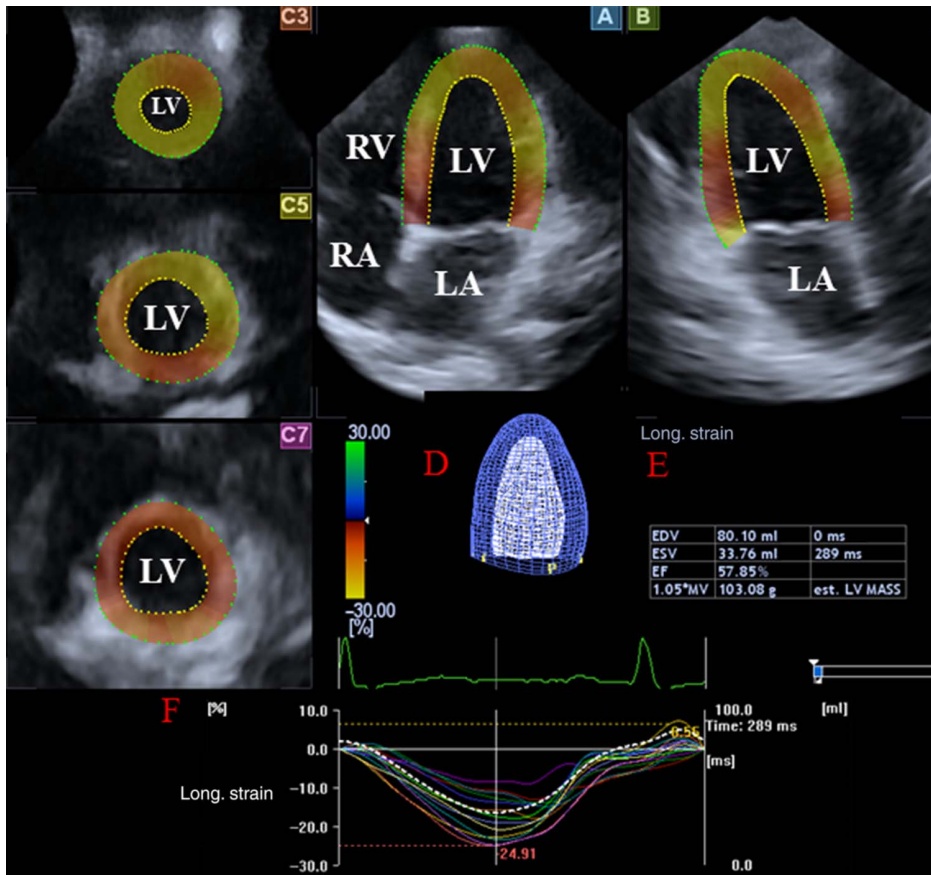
Different views of the LV extracted from the 3D echocardiographic data set are presented including apical four-chamber (A) and two-chamber views (B) and basal (C3), midventricular (C5), and apical (C7) short-axis views. A 3D LV model (D) and calculated volumetric LV parameters are also demonstrated (E) together with segmental LS curves (F) in an elite athlete. LV: left ventricle; RV: right ventricle; LA: left atrium; RA: right atrium; EDV: LV end-diastolic volume; ESV: LV end-systolic volume; EF: LV ejection fraction; est. LV MASS: estimated LV mass
